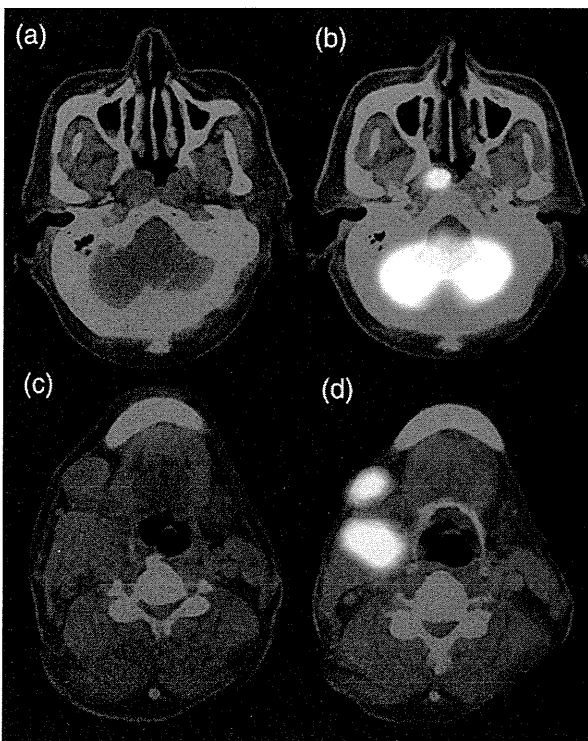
F-MISO PET/CT (a, c), and FDG PET/CT (b, d) for a patient with nasopharyngeal cancer (case 8: T1N2bM0). In this patient, no significant F-MISO accumulation was observed in the primary tumor (SUVmax; 1.20) or metastatic lymph nodes (1.35), although strong FDG uptake was noted.
